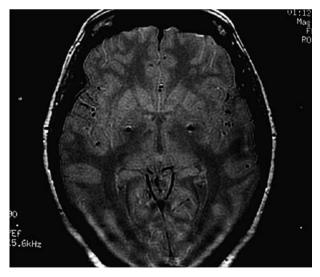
Postoperative stereotactic axial MRI scan at the anterior commissure-posterior commissure level, showing DBS electrode artifacts in the posteroventral GPi (arrows)
